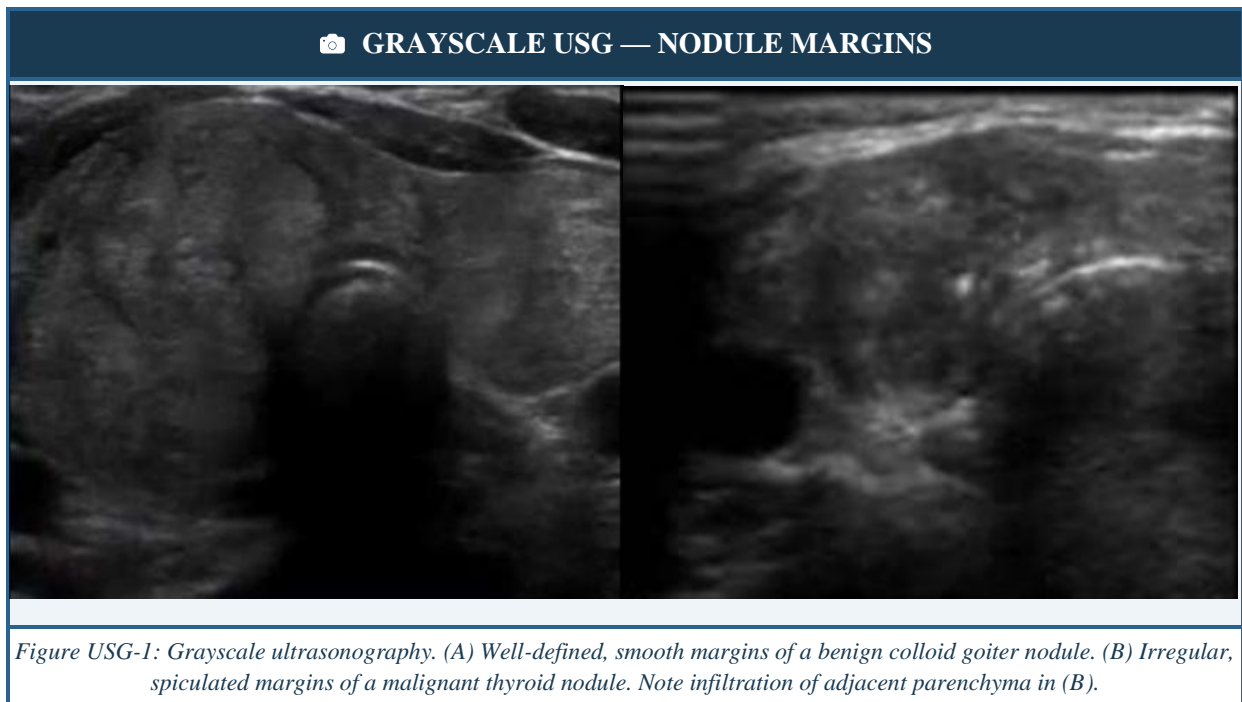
Figure USG-1: Grayscale ultrasonography. (A) Well-defined, smooth margins of a benign colloid goiter nodule. (B) Irregular, spiculated margins of a malignant thyroid nodule. Note infiltration of adjacent parenchyma in (B).
